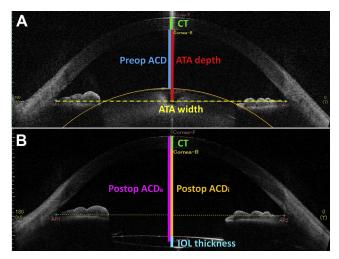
Measurement of anterior segment parameters via anterior segment optical coherence tomography images (A) before and (B) after cataract surgery. ACD = anterior chamber depth; ACD_e = external anterior chamber depth; ACD_i = internal anterior chamber depth; ATA = angle-to-angle; CT = corneal thickness; IOL = intraocular lens; postop = post-operative; preop = preoperative.
